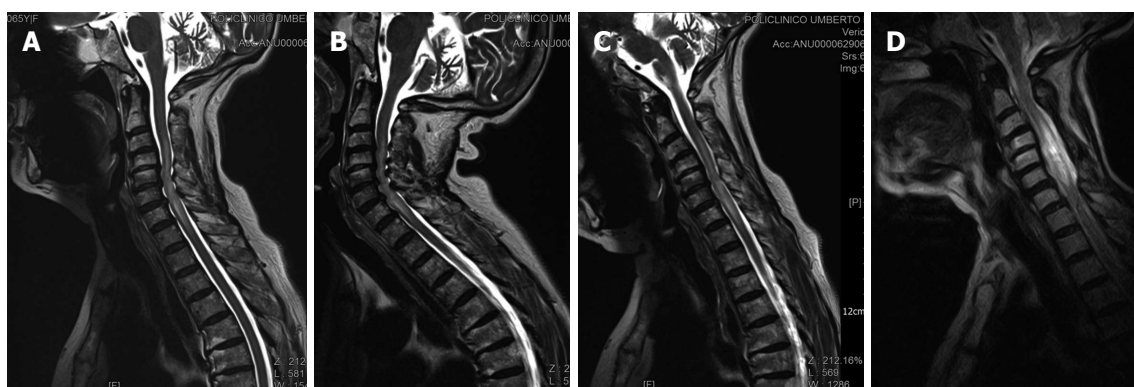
Preoperative magnetic resonance imaging. A: T2-weighted magnetic resonance imaging revealed hyperintensity of the central spinal cord extended from C3 to T1 without clear borders. In the inferior cervical spinal cord hyperintensity appeared more evident suggesting syrinx; B and C: At the same level cervical spinal cord compression was determined by bulging discs, facets and ligamenta flava hypertrophy, more evident in hyperextension (B) rather than flexion (C); D: It revealed enlargement of the syrinx, but decreased longitudinal extension of “central cord syndrome” bounded from C3-C4 to C7 with clearer borders. At the level of surgical decompression also spinal cord and subarachnoid space appeared expanded.
